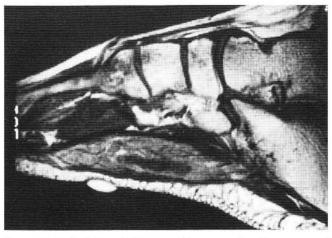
Sagittal plane MRI of an adolescent male with a mass and reduced sensation in the plantar right foot. The lesion is located just below the plantar fascia. The image depicts the extent of the lesion.
